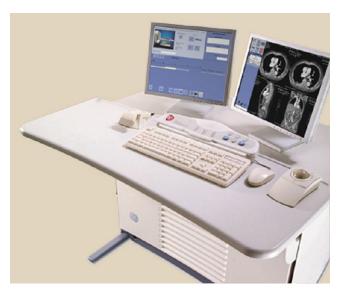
Operator's console for a multislice spiral computed tomography imaging system. (Courtesy Reggie Carter, GE Healthcare.)
